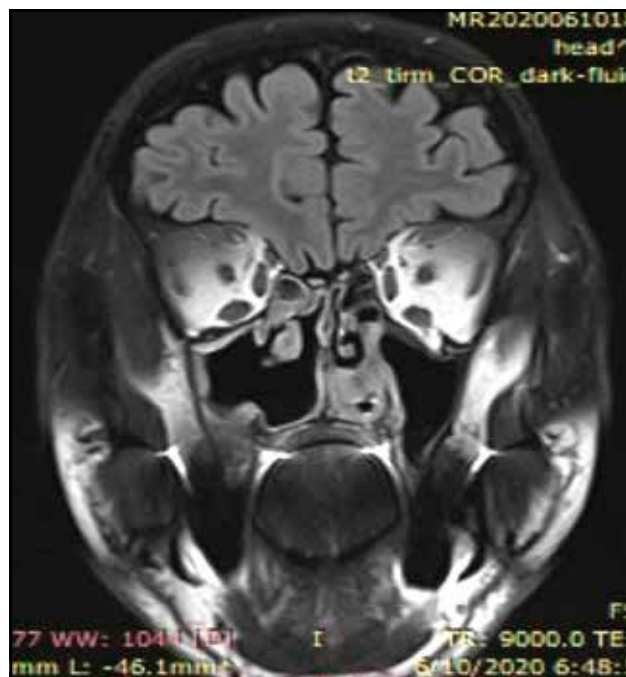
Cranio-facial MRI (coronal and axial slices). Absence of the medial wall of the maxillary sinus, without MRI signs of tumor areas in the right maxillary sinus, ethmoidal cells or nasal fossa. Normal aspect of the orbital contents.
